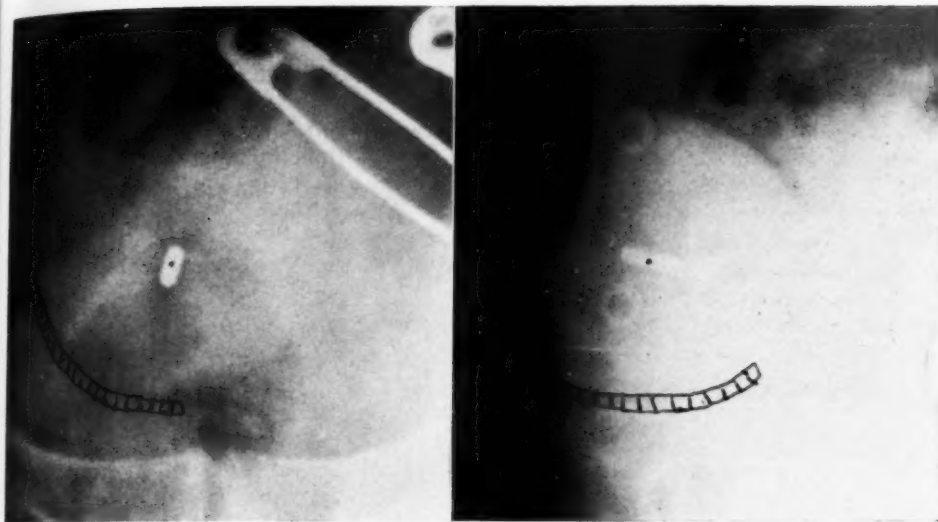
Anteroposterior and lateral views of radium in a recent patient not included in the series reported here. The shaded area indicates the residual base of a broad, sessile, papillary carcinoma. The active length of the radium source is 1 cm., and filtration is 0.5 mm. Pt. The small dot marks the center of the radium source; from this point, distances are measured. The total diameter of the bag was 4.5 cm. However, inflation of the bag was eccentric, so that radium-tissue distance was calculated, with the aid of these roentgenograms, to be 2.1 cm. Since the radium was closer to and delivered a larger dose to the tumor than to the normal bladder mucosa, an ideal situation was obtained. If these relationships are reversed, the catheter is replaced immediately. The string, attached to the tip of the removed catheter, is tied to the new catheter and assists in inserting it into the bladder.
